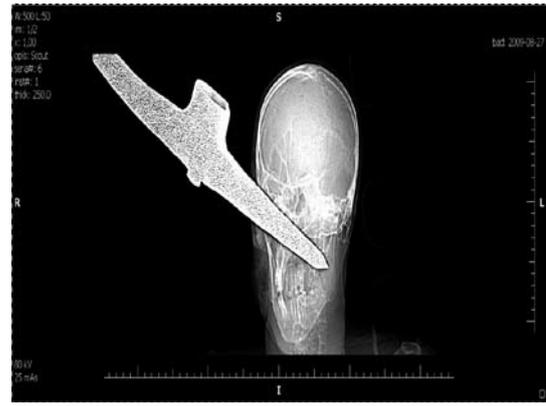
CT image of the skull with a stuck pickaxe
